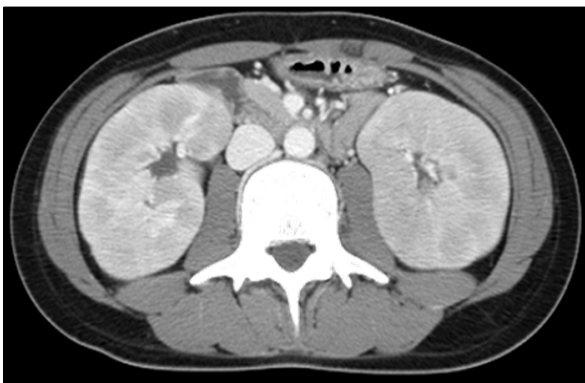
Initial abdominal CT. Abdominal CT reveals diffuse parenchymal swelling of both kidneys.
